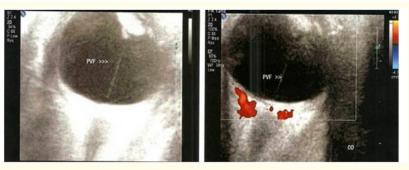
Left: Postnatal B-scan ultrasound demonstrating a tubular stalk of fibrous tissue extending from the optic disk toward the opacified lens, as seen in PFV. Figure 2 Right: Color Echo-Doppler imaging disclosed blood flow in choroidal and retinal vessels but disclosed no blood flow inside the stalk.
